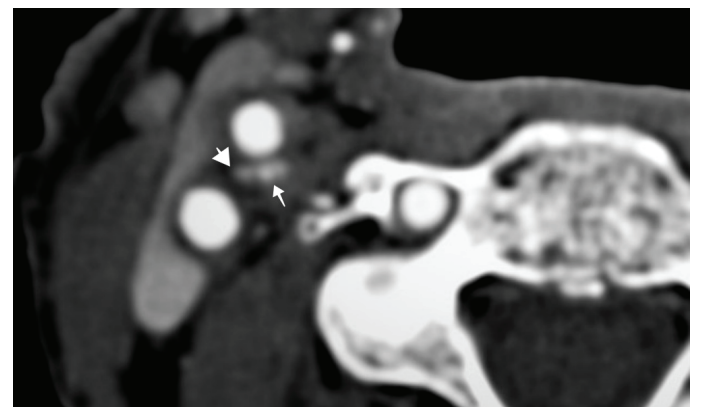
Axial CT image. CB in the right carotid bifurcation (arrow) and a branch of external carotid artery adjacent to CB (arrowhead).
